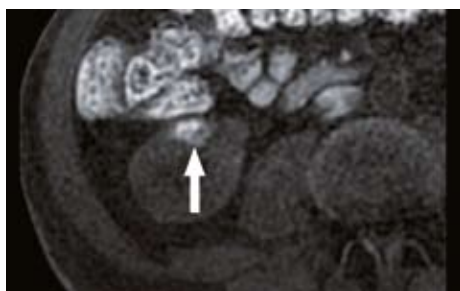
h and i: Contrast-enhanced MRI confirmed the successful treatment after one year. Note that the non-enhanced fat suppressed T1-weighted gradient acquisition is mandatory to detect the hypersignals due to coagulation necrosis, and avoid misdiagnosis of tumor recurrence.
